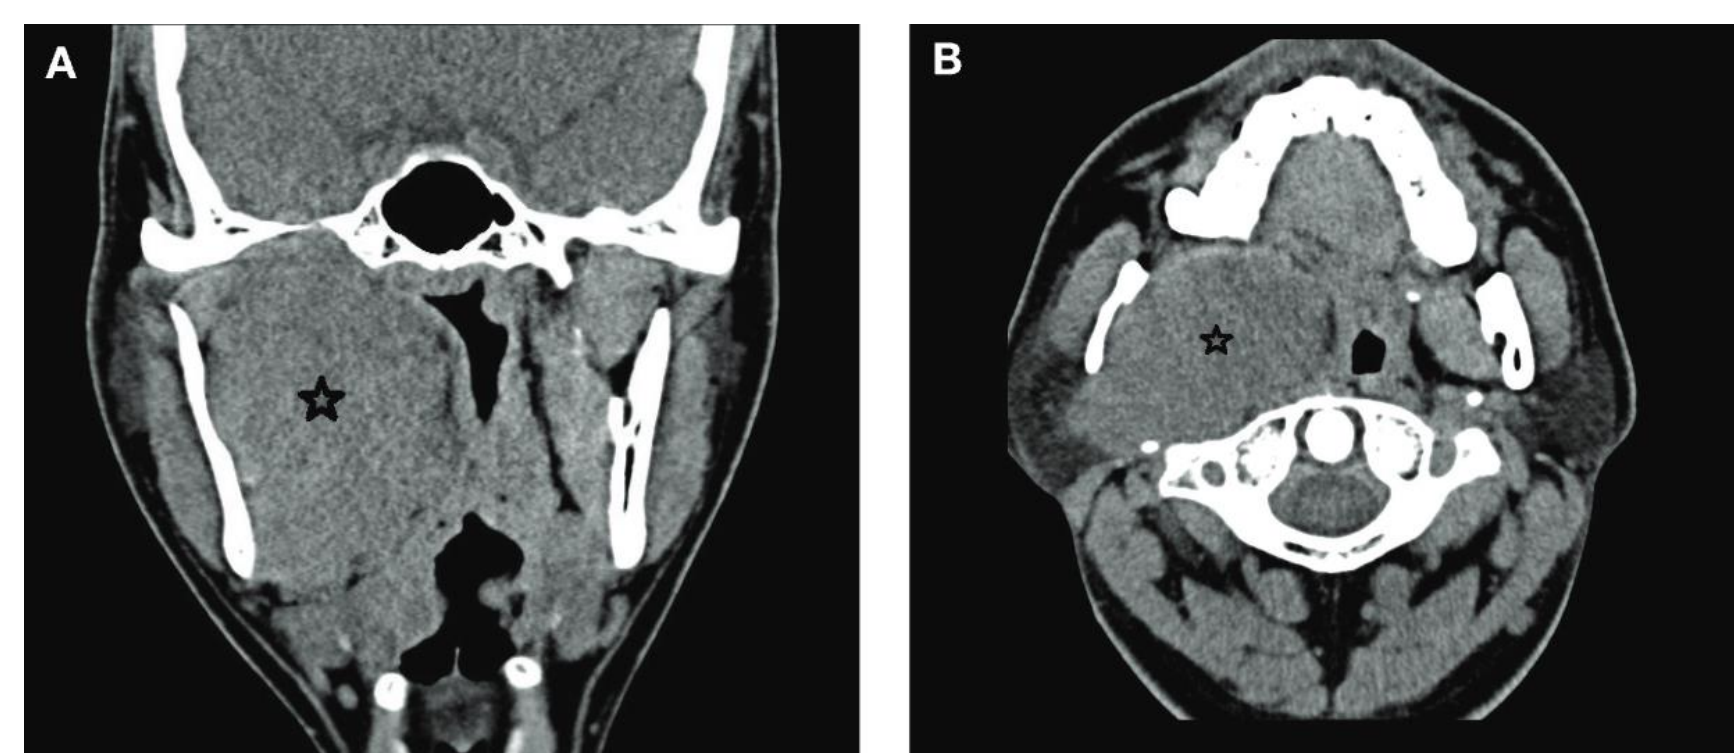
Image showing a leiomyosarcoma of the right parapharyngeal space (indicated with a star). A) coronal CT. B) axial CT. Image source: Locatello et. al.<sup>5</sup>
